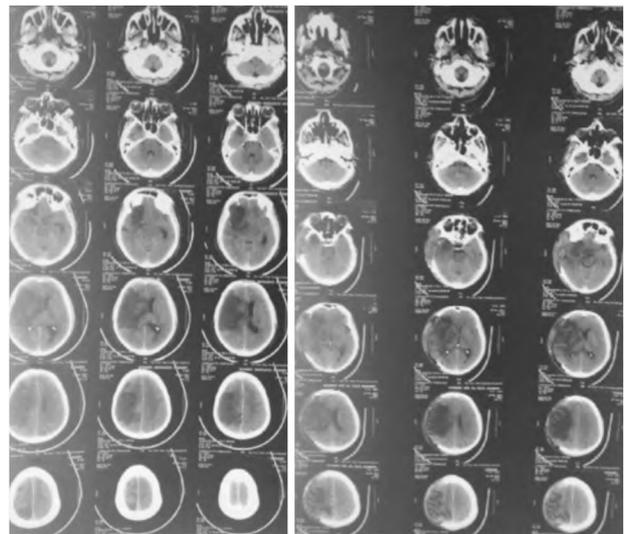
(A) CT scan of right malignant middle cerebral artery infarction. B) After decompressive hemicraniectomy.
